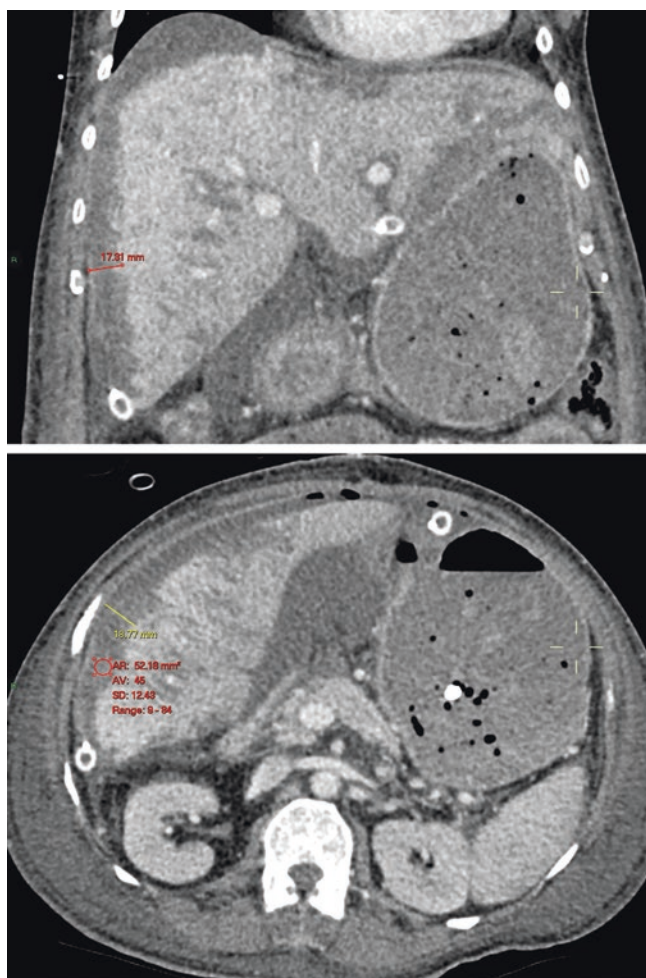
Coronal (top image) and Axial (bottom image) CT scan from a patient post liver transplantation. A large crescent shaped subcapsular haematoma is seen (measured at approximately 18 mm in depth). This fluid is of high attenuation on CT (Hounsfield units measured at 45) consistent with haematoma. The compressive effect of the subcapsular haematoma gives the donor graft an irregular contour
